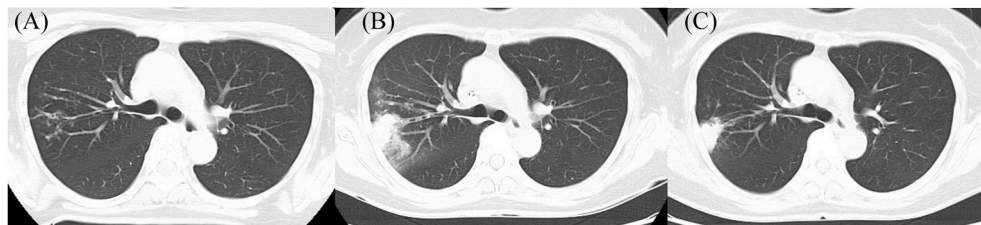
(A) Chest computed tomography (CT) images at first presentation showing small nodular shadows and bronchiectasis in the right upper lobe. (B) Chest CT images showing ill-defined consolidation with neighboring granular shadows in the right upper lobe on the date of hospital admission. (C) Chest CT images showing reduction of the infiltrating shadows in the right upper lobe on the 29th hospital day.
